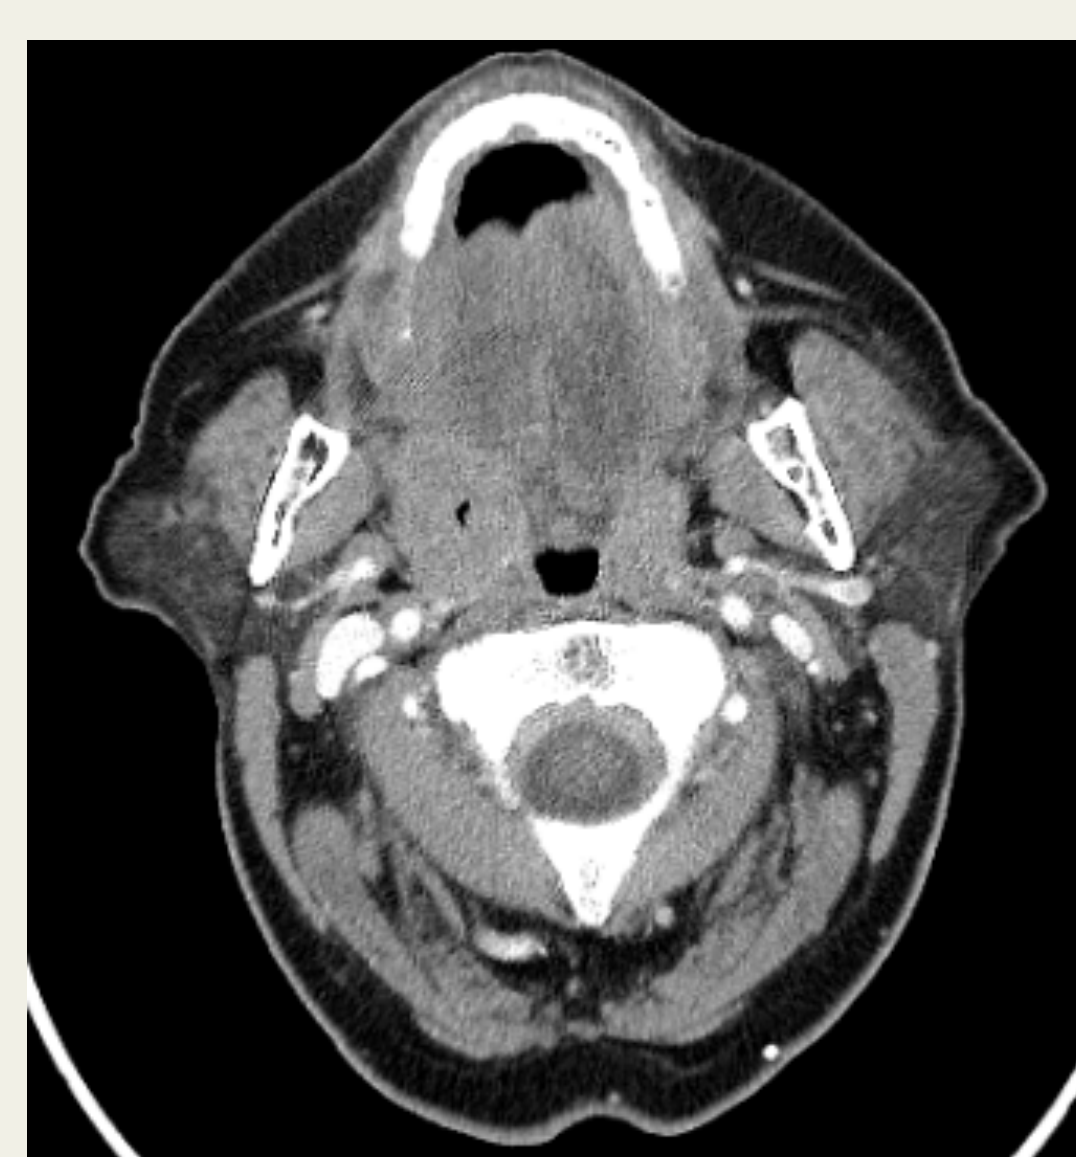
Contrast CT showing 4.0 x 2.1 x 1.6 cm right tonsil mass with on cervical adenopathy
